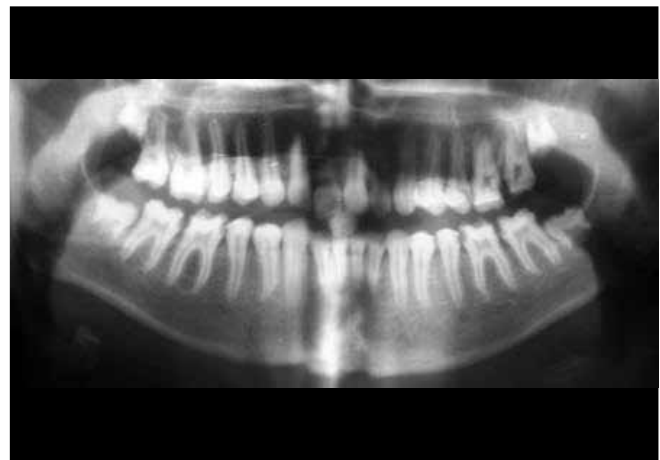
Orthopantomogram
